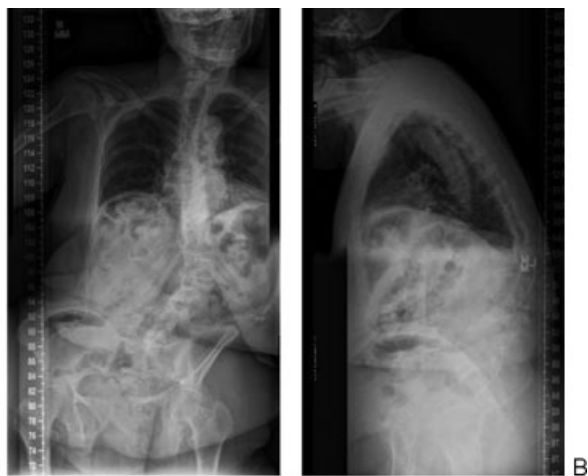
Preoperative (A) anteroposterior and (B) lateral standing X-ray.
